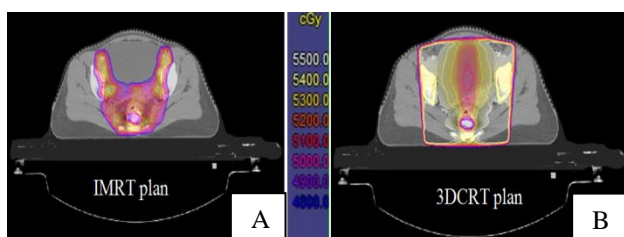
Dose distribution in axial CT slices of same patient being planned for IMRT and 3DCRT respectively.
